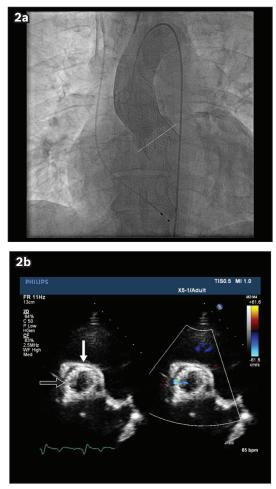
(a) Fluoroscopic image of an aortogram shows the CoreValve[®] post deployment, with no leakage of dye toward the left ventricular cavity. The white line indicates the annular plane of the native aortic valve. (b) Parasternal short axis transthoracic echocardiography at one month shows a well-expanded valve (open arrow) within the native aortic annulus (white arrow).
